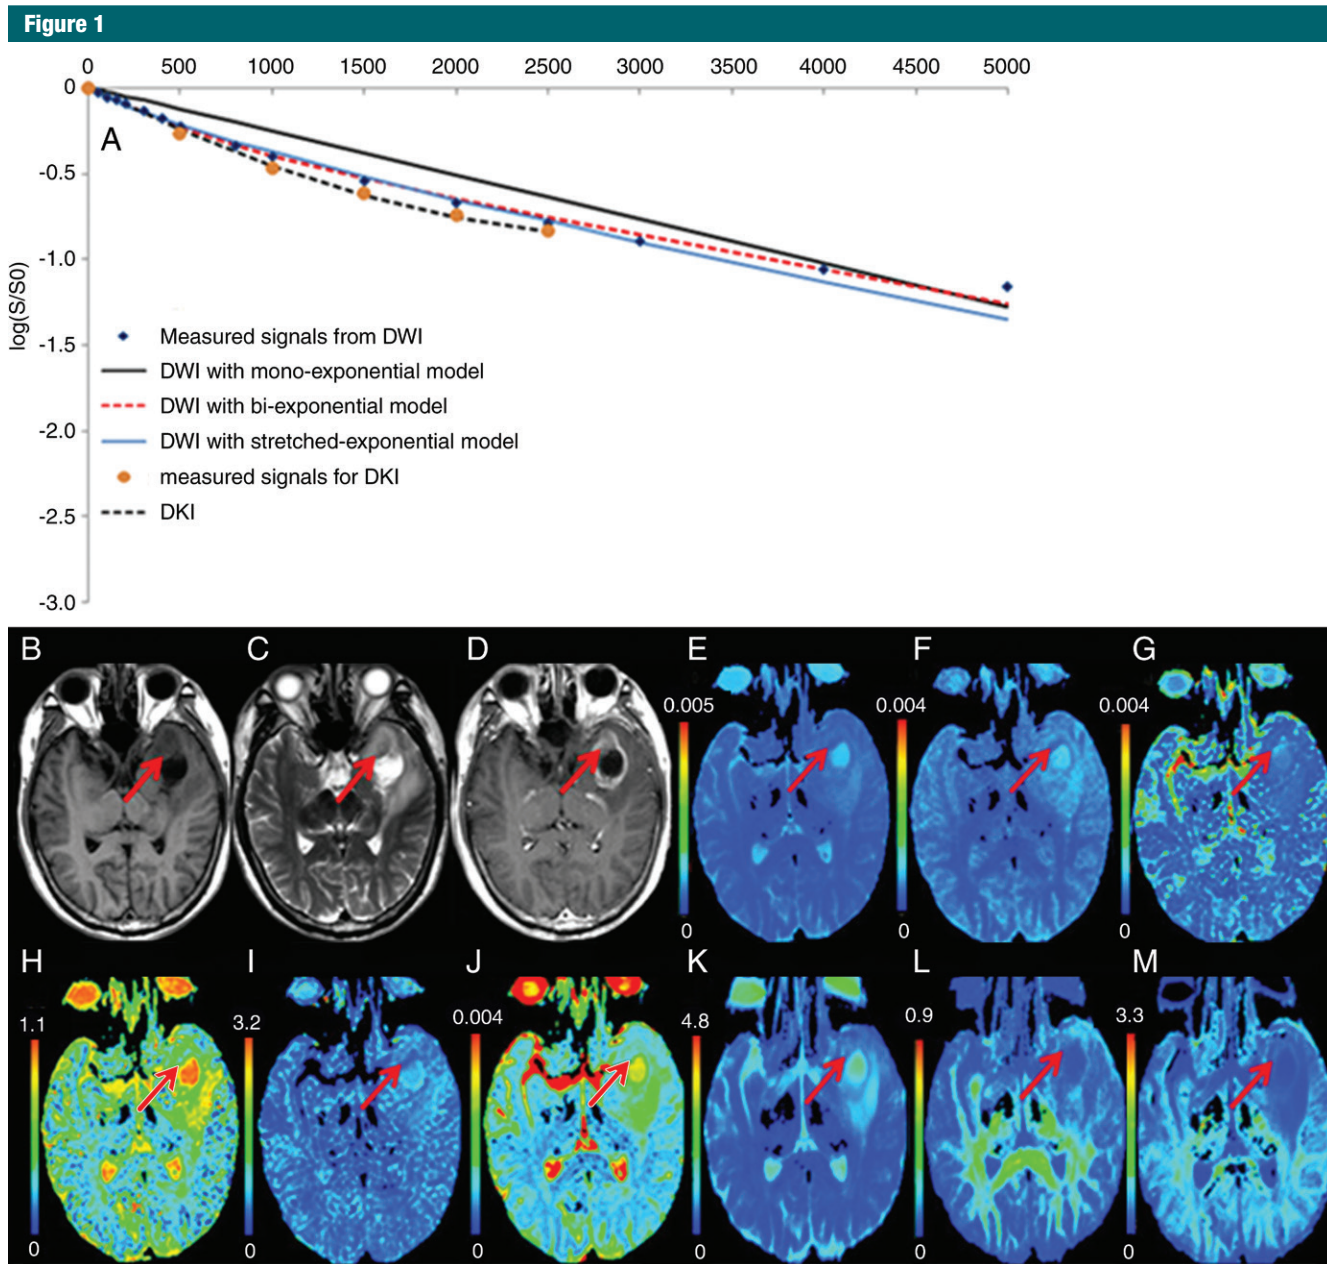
High-grade glioblastoma (WHO grade IV) in the left temporal lobe (arrows) in a 61-year-old woman. *A*, The curves of different fits were derived from DWI by using monoexponential, biexponential, and stretched exponential models and DKI. *B*, T1-weighted MR image shows that the tumor is hypointense. *C*, T2-weighted MR image shows that the tumor is hyperintense. *D*, Gadolinium-based contrast material–enhanced T1-weighted MR image shows that the tumor has irregular enhancement. In the solid tumor component that enhances with gadolinium-based contrast material, *E*, the ADC map and *F*, the ADC_{slow} map show decreased values. *G*, The ADC_{fast} map shows increased values, and *H*, the *f* map, *I*, α map, *J*, DDC map, and *K*, mean diffusivity map show decreased values. The *L*, FA and *M*, MK maps show increased values.
